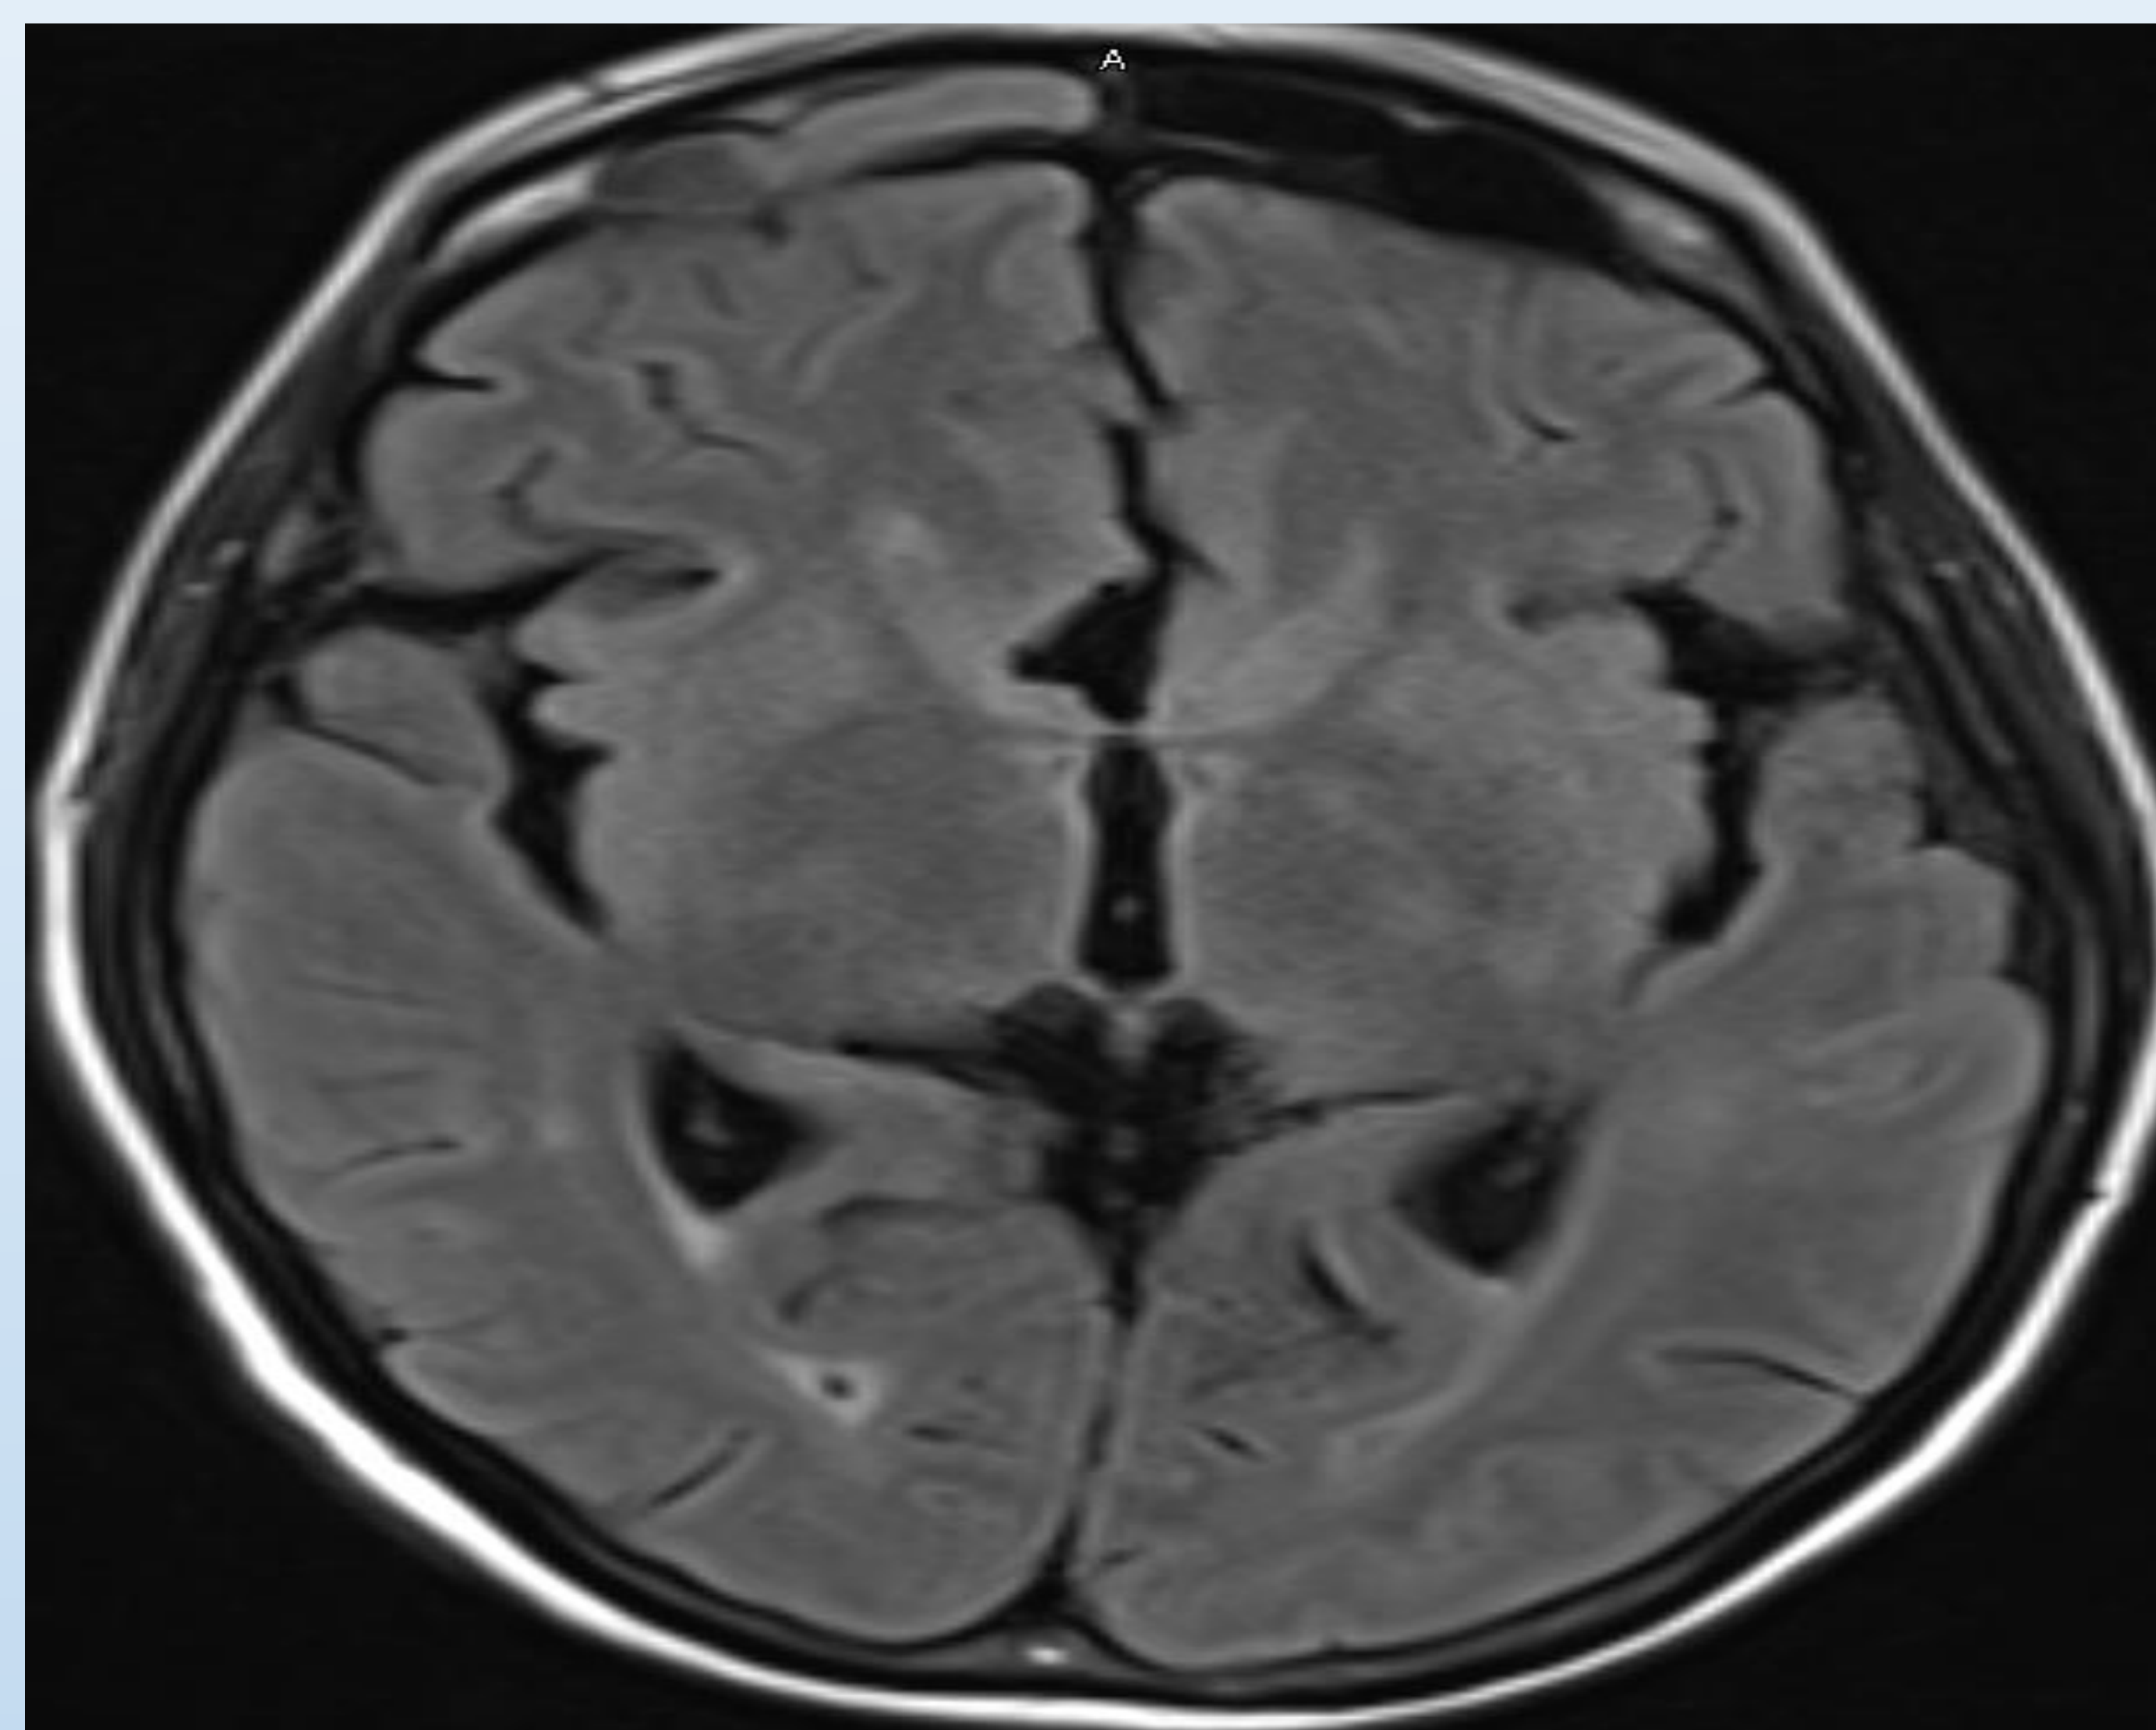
MRI showing patchy and confluent hyperintensity in the periventricular and subcortical white matter.
